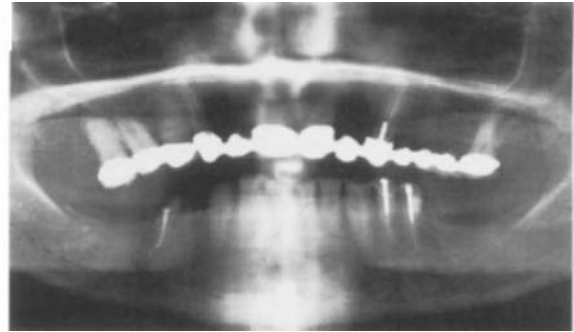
■ Panoramic preoperative radiograph showing bilateral posterior edentulism in mandible.
